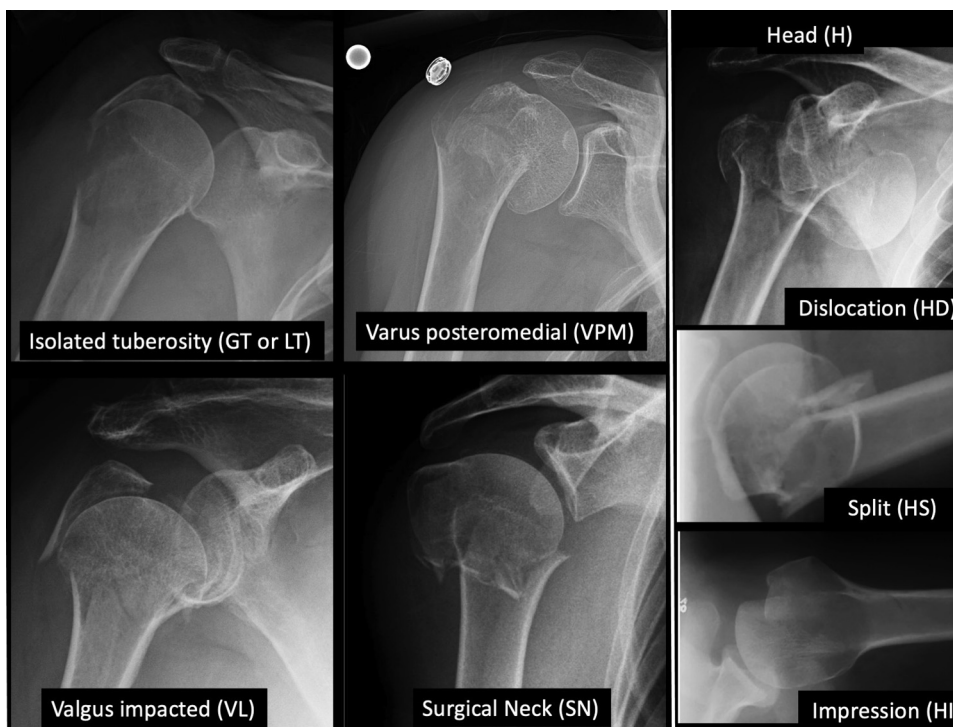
Radiographic examples of the 7 major patterns of proximal humerus fractures for the Mayo-FJD classification.
